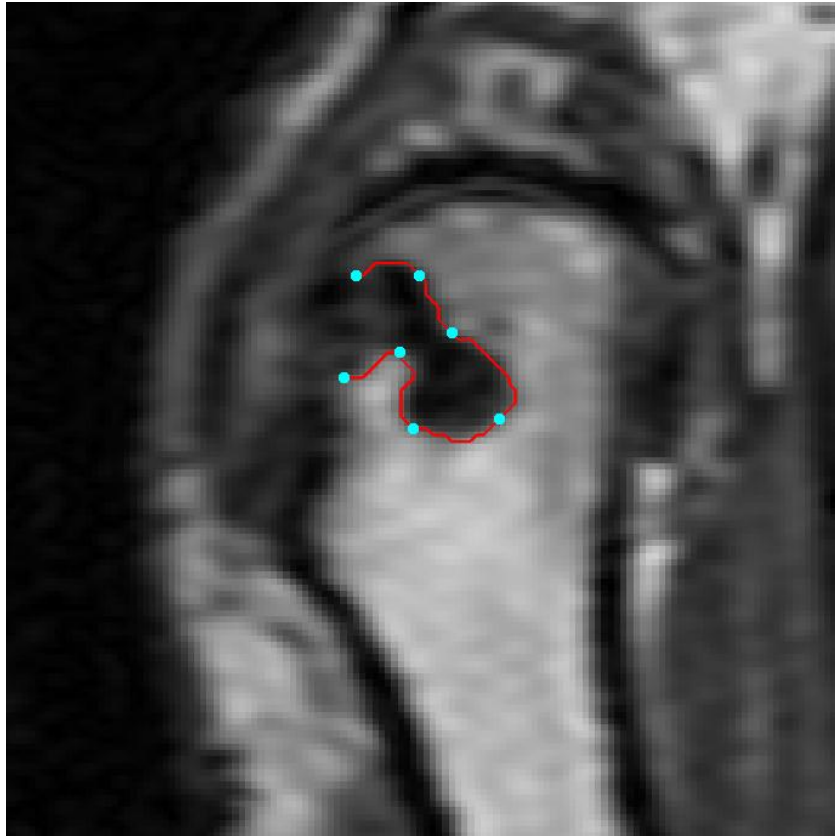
An example of Dijkstra's algorithm used to guide the manual tracing of a typical bone erosion in an MR image. The red line was determined by the algorithm and represents the shortest path between manually chosen pixels, which are denoted by light blue circles.
